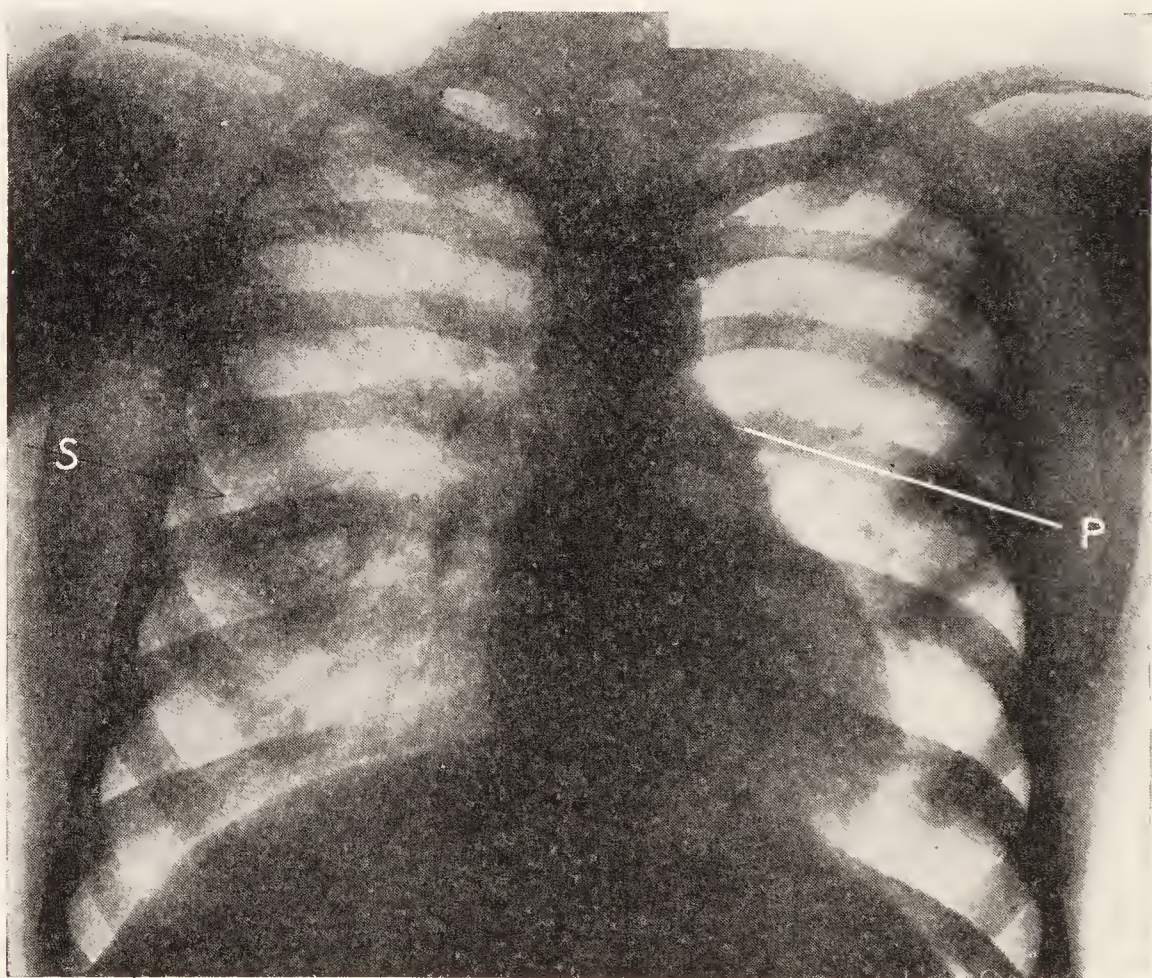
Case LXIX. P.—Projection often seen in congenital heart disease. S—Thickened interlobar septum. (Roentgenological Department, Massachusetts General Hospital.)
